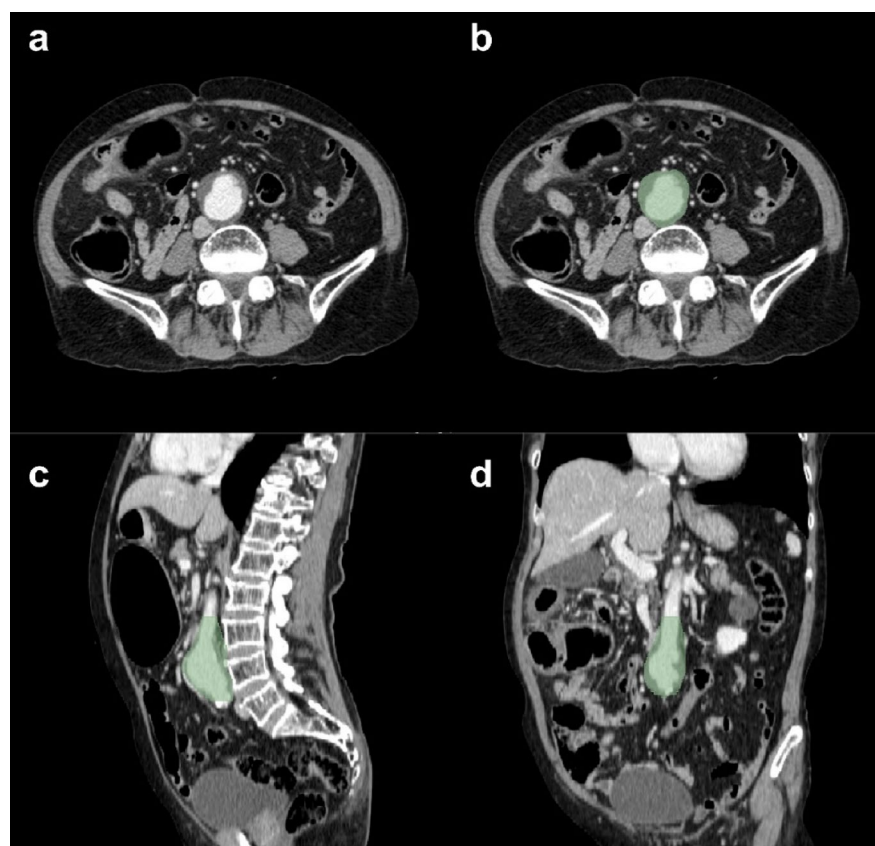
AAA annotation on CT image using 3D slicer program. (a) CT window level and window width applied to the CT image in the axial view. (b) Aorta annotation in the axial view. (c) Aorta annotation before the renal arteries, verified in the sagittal view. (d) Aorta annotation from the aortic bifurcation, verified in the sagittal view.
